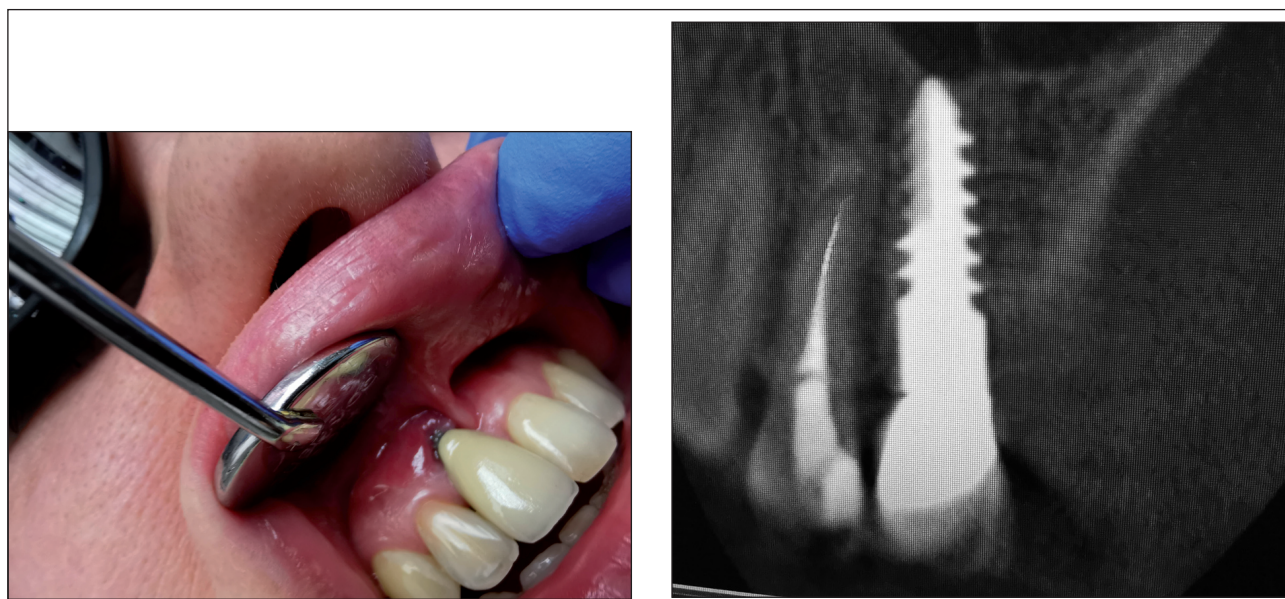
3 b. Peri-implant mucositis clinical and radiographic presentation (before treatment)
